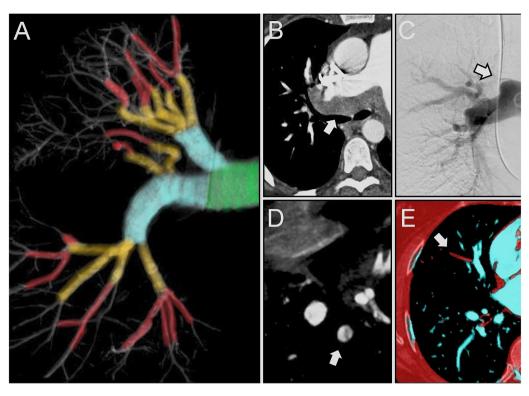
Location classification of chronic thromboembolic lesions. (A) Three-dimensional cone beam CT-pulmonary angiography (CBCT-PA) reconstruction in a 65-year-old man with suspected chronic thromboembolic pulmonary hypertension (CTEPH): *Level I:* lesions beginning in the main pulmonary artery (PA) (green). *Level II:* lobar arteries (blue). *Level III:* segmental level (yellow). *Level IV:* subsegmental level (red). (B) Single-energy CT pulmonary angiography image in the axial plane in a 56-year-old man demonstrates involvement at the level of the main PA (arrow, *level I).* (C) Digital subtraction pulmonary angiography of another patient (36-year-old woman) shows involvement beginning at the lobar level (arrow, *level II).* (D) CBCT-PA in a 72-year-old woman with confirmed CTEPH demonstrates lesions affecting the segmental level (arrow, *level III).* (E) Dual-energy CT-pulmonary angiograph iodine map in a 43-year-old-man depicts subsegmental perfusion defects (arrow, *level IV).*
